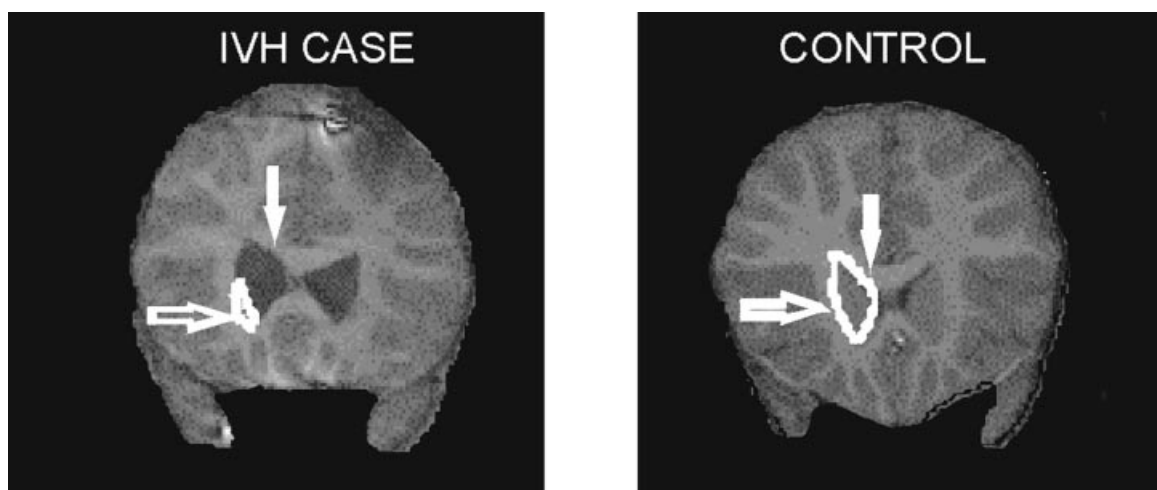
Representative MRI coronal slice from 2 preterm children, 1 with IVH of grade III and IV (left) and one without (right). The caudate nucleus is outlined in white for each subject. Note how the ventricles are distended at the expense of the caudate nucleus for the child with IVH.
